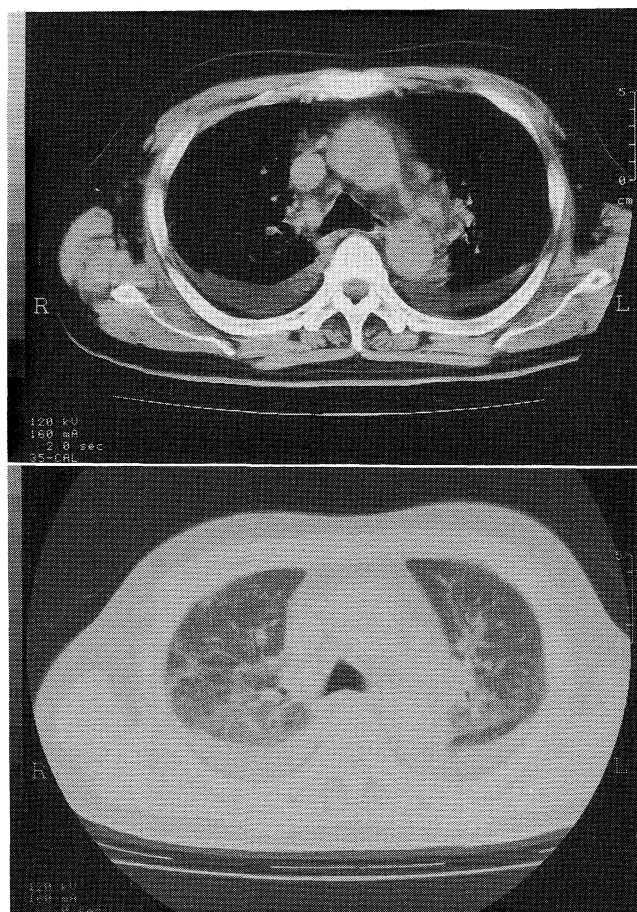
Chest CT on admission also shows diffuse linear and reticular shadows in the bilateral lung fields, bilateral pleural effusion, and the enlargement of bilateral hilar lymph nodes.
